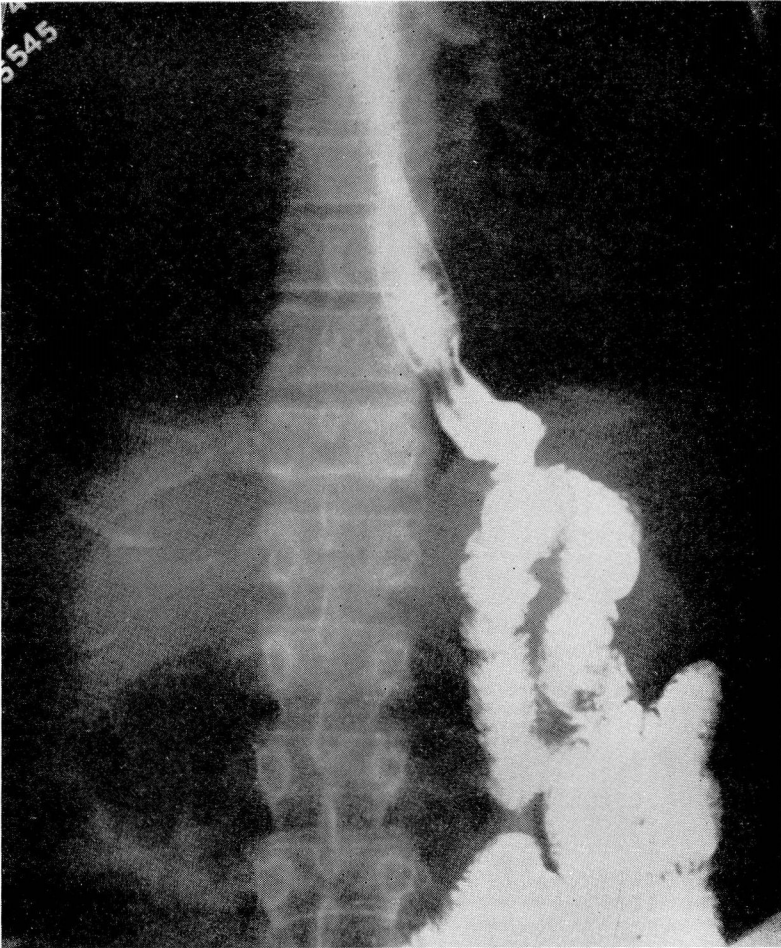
Roentgenogram after a barium meal, showing the stoma to be functioning well.
